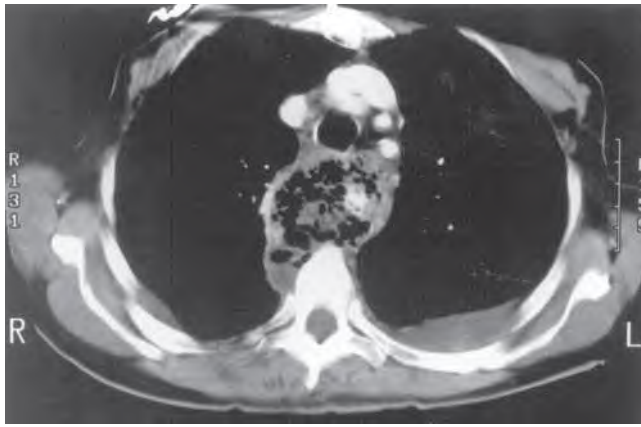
Mediastinitis. Computed tomography scan of the chest at the level of the sixth thoracic vertebra shows large abscess within posterior mediastinum and left-sided pleural effusion. The patient had experienced perforation of the esophagus owing to a swallowed foreign body. (From Rupp ME. *Mediastinitis*. In: Fishman AP, Elias JA, Fishman JA, et al, eds. *Fishman's Pulmonary Diseases and Disorders*. 3rd ed. New York: McGraw-Hill; 1998:2036–2043.)
